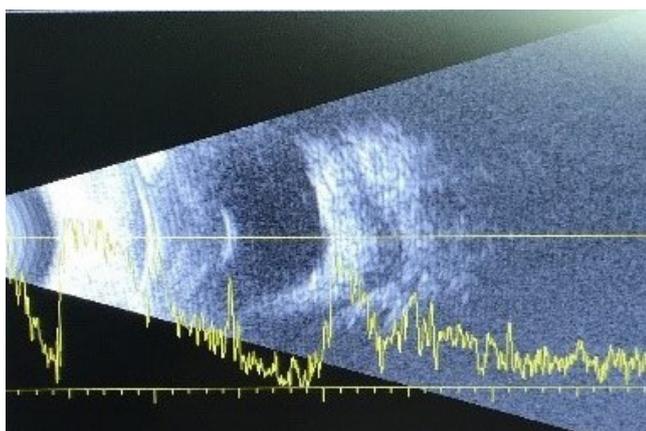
B-scan ultrasound of the right eye demonstrates a diffuse choroidal tumour.
